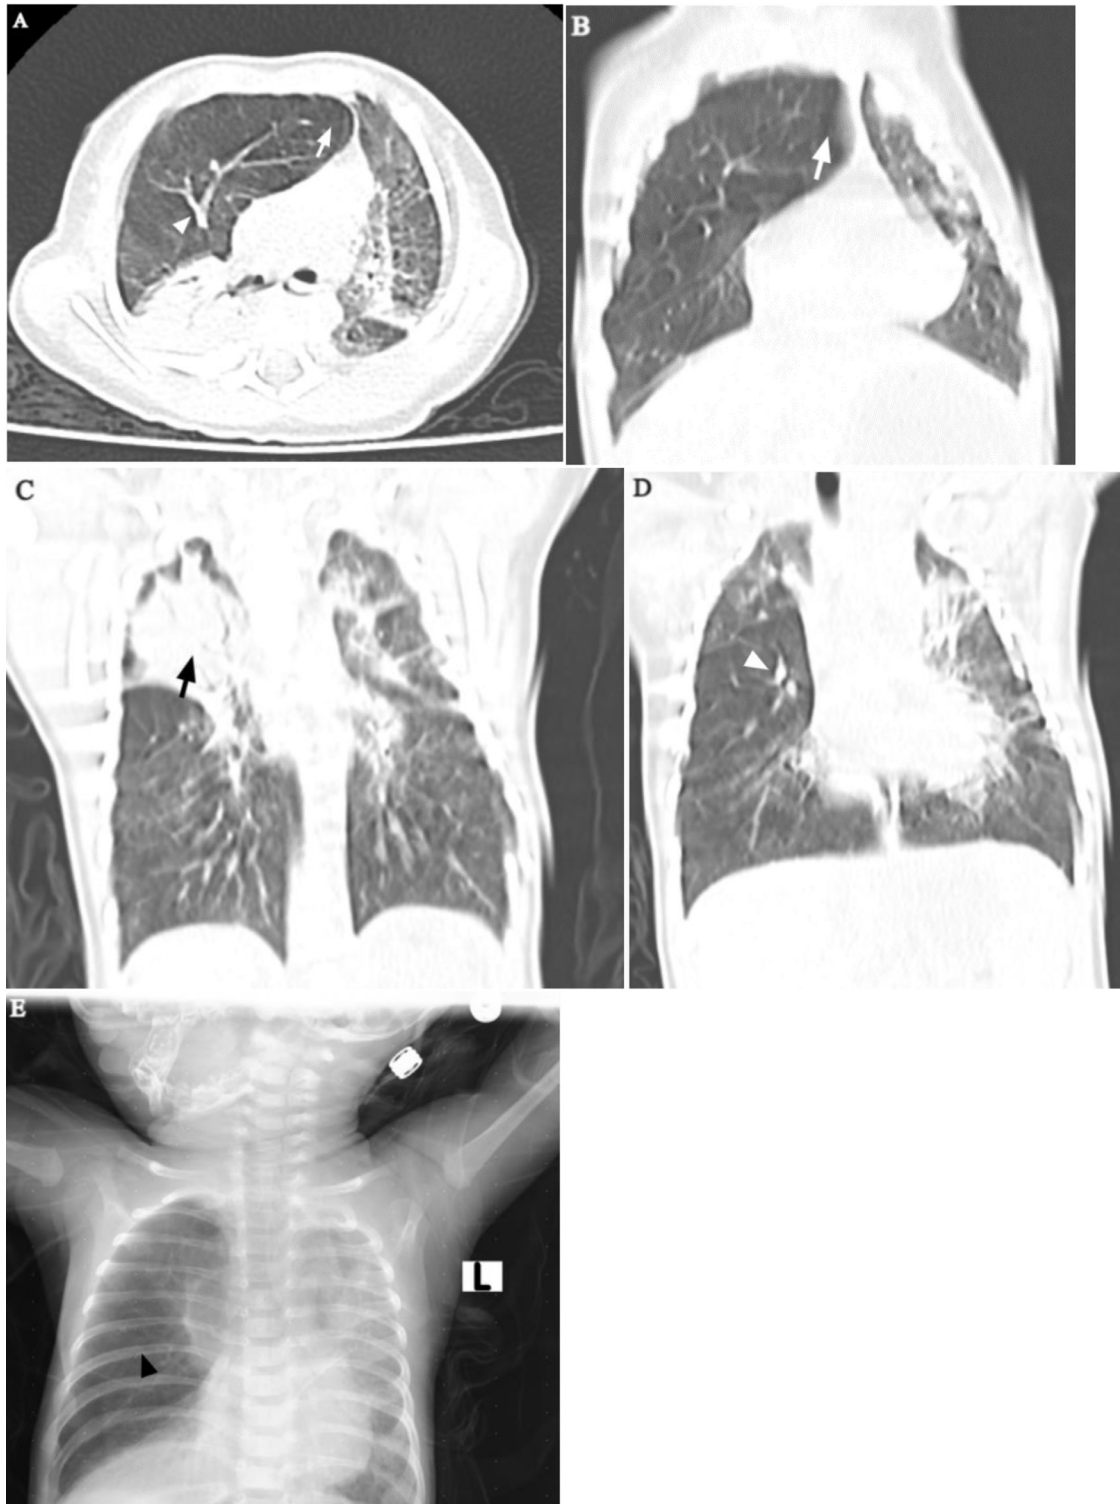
Axial (A) and successive coronal views (B-D) of chest CT in lung window show hyperinflated RML with left ward herniation through the anterior mediastinum (white arrows). Caliber of vessels are relatively preserved (white arrowheads in A and D). Consolidation is seen in the posterior segment of the right upper lobe (black arrow in C). Chest radiograph (E) acquired 14 days after the chest CT shows resolution of consolidation but persisting large area of lucency (black arrowhead) in right lung consistent with RML overinflation.
